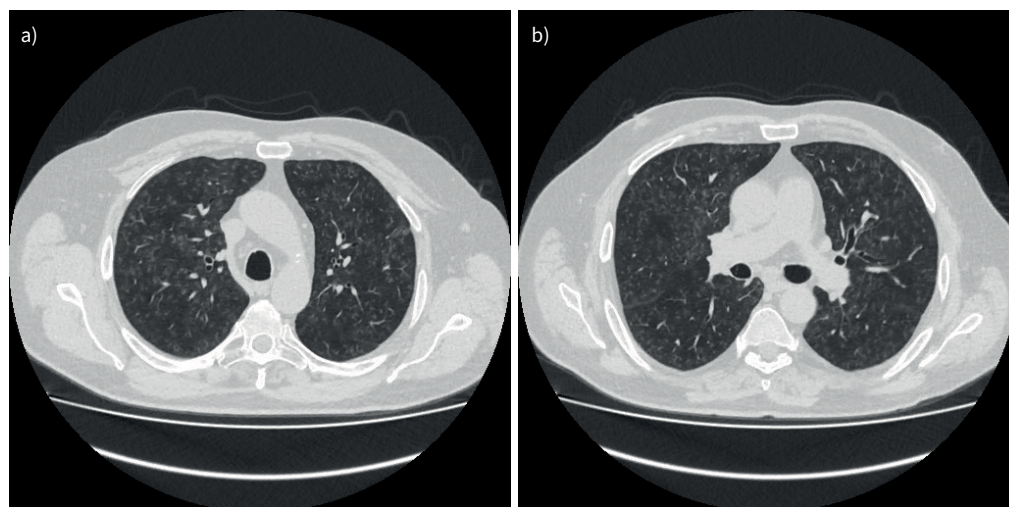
a, b) Chest computed tomography 1.5 months after the images shown in figure 2 (1 month after the gradual withdrawal of corticosteroids): extensive bilateral ground-glass opacities, small centrilobular nodules and mosaic attenuation.
